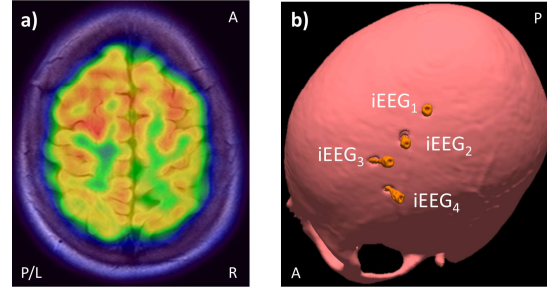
a) A sagittal slice of fludeoxyglucose positron emission tomography (FDG-PET) that showed a slight hypometabolism in the left superior frontal gyrus, suggesting a possible functional deficit zone; b) The reconstructed skull (pink color) with four invasive electrodes – IEEG (namely, IEEG₁, IEEG₂, IEEG₃ and IEEG₄, orange color) were implanted into the suspect deep sulcus and the left superior frontal gyrus (left and middle sketches) and the iEEGs within the skull. The letters, A, P, L and R denote 'anterior', 'posterior', 'left' and 'right' respectively.
